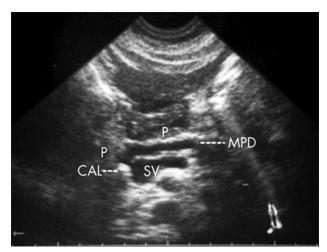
Ultrasonography abdomen
